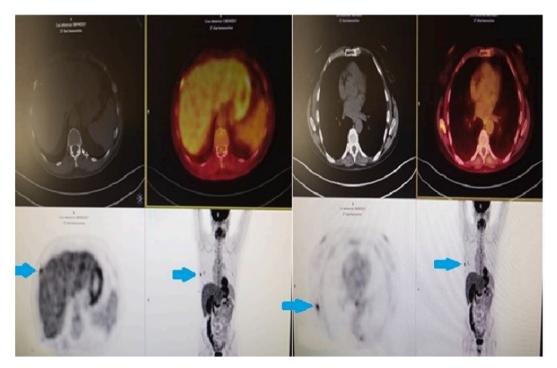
PET/CT scan. Bone metastases in the seventh right costal arch and the right scapular tip are indicated by arrows.
